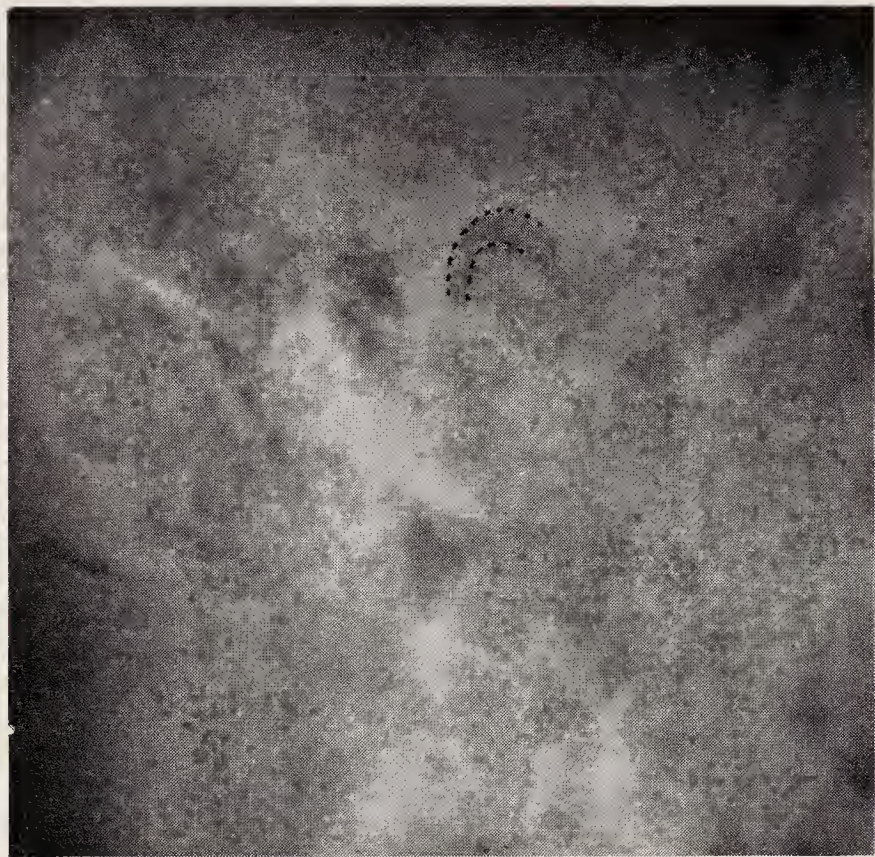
Radiograph of normal joint space.
